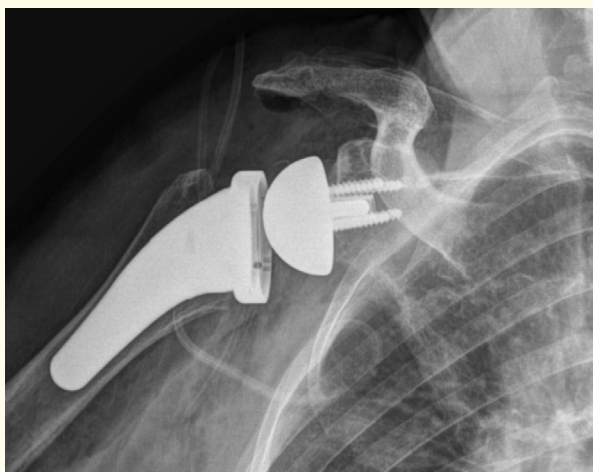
Post-operative radiograph of right shoulder.
